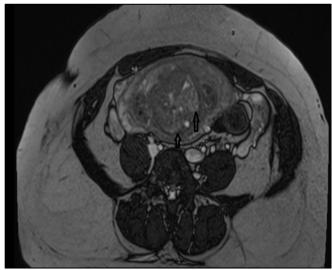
Axial Section Passing Through the Empty Renal Chambers. (MRI T2 Sequence)
